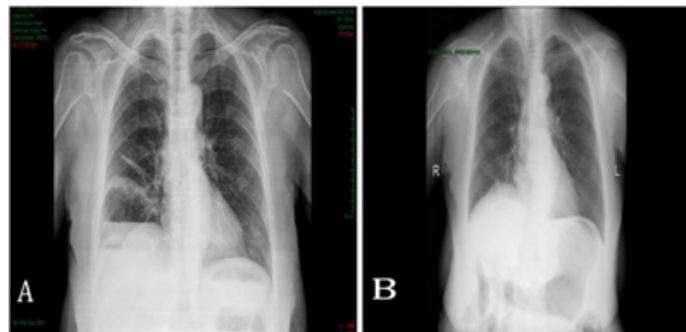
2A. Chest x-ray before herniorrhaphy, 2B. Chest x-ray after herniorrhaphy.
